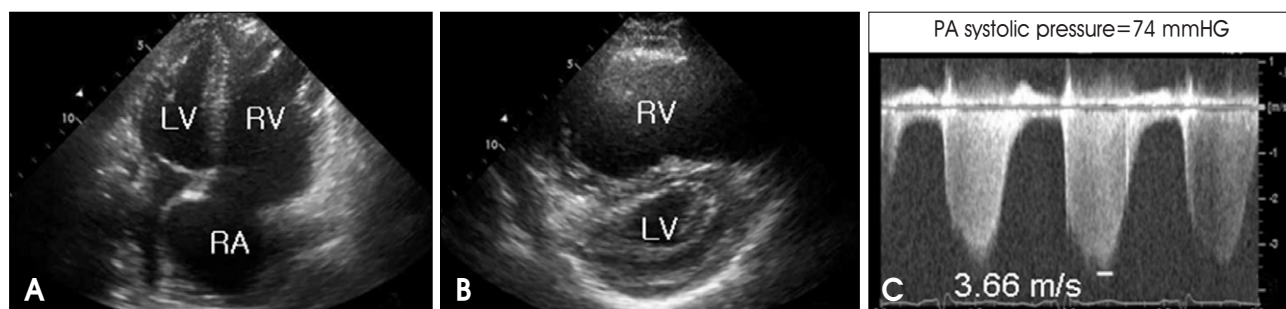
Initial transthoracic echocardiography for severe dyspnea. Significantly enlarged RV and RA and D-shaped LV were observed (A, B). Calculated PA systolic pressure is 74 mmHg (C). She was diagnosed with acute pulmonary embolism. RV: right ventricle, RA: right atrium, LV: left ventricle, PA: pulmonary artery.
